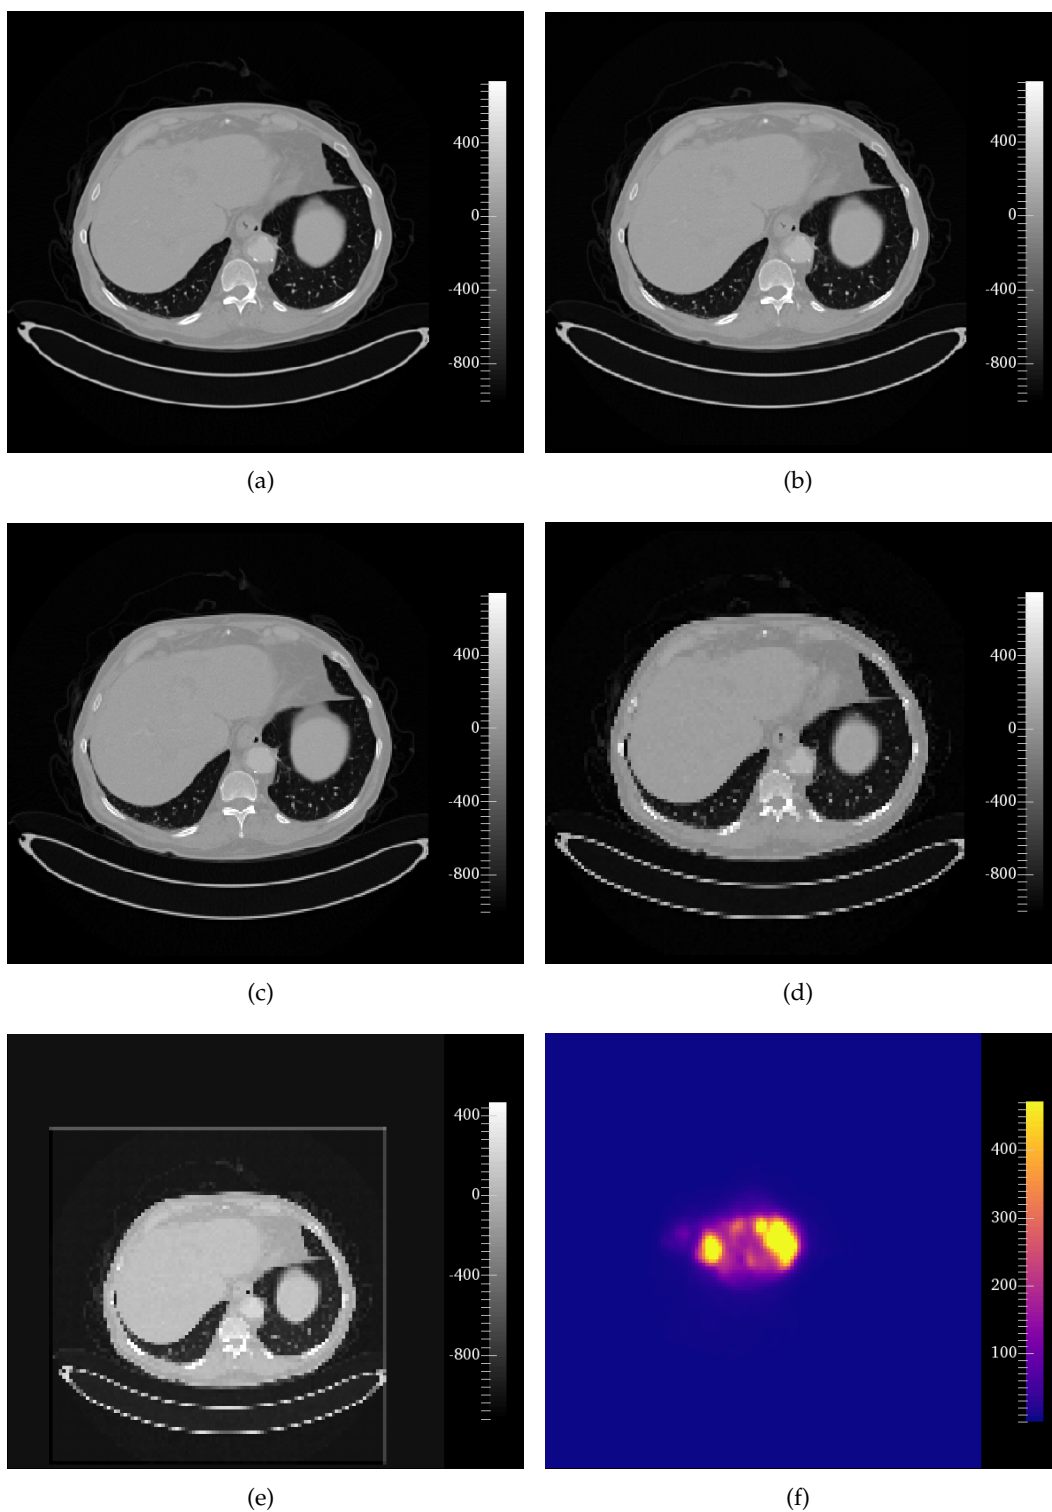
Axial views of the native CT (a), of the various resampled CTs - R2 (b), R8 (c), R64 (d), RS (e) -, and of the Tc-MAA SPECT (f). All the images have no graphical smoothing of the actual slice pixels, in order to appreciate as much as possible the different resolutions.
